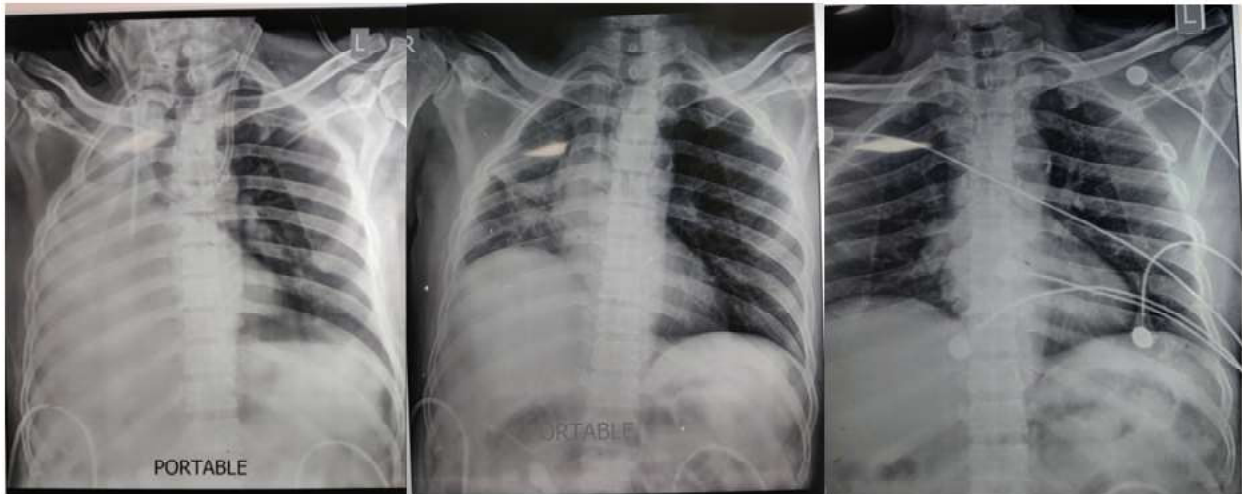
Chest X-ray show Complete collapse of right lung with ipsilateral shift of trachea on 3<sup>rd</sup> POD.
